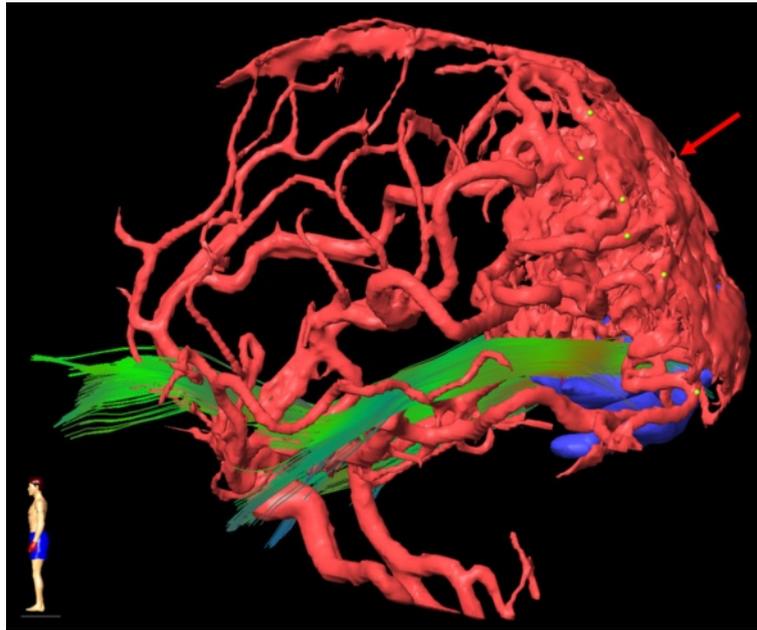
Case 42. A 3D reconstruction of BOLD-MRI, DTI, and TOF-MRA showing the relationship of the AVM (red arrow), optic radiation (green), and visual cortex (blue)
